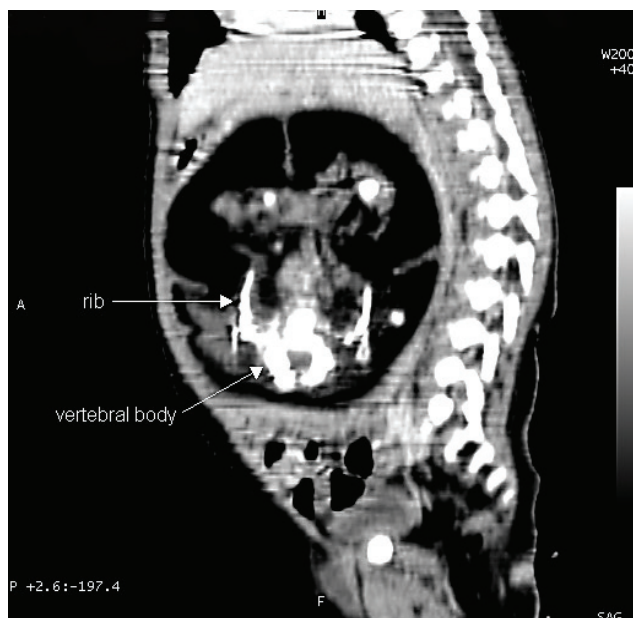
Computed tomography, sagittal view, depicting a huge, complex and septated intraabdominal mass with opacities representing the vertebral body and rib.
